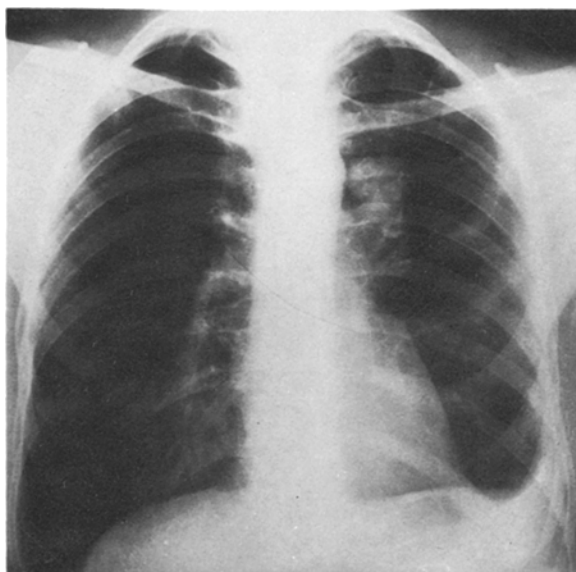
A-P roentgenograph showing tumorous mass in the central part of the left hilus
